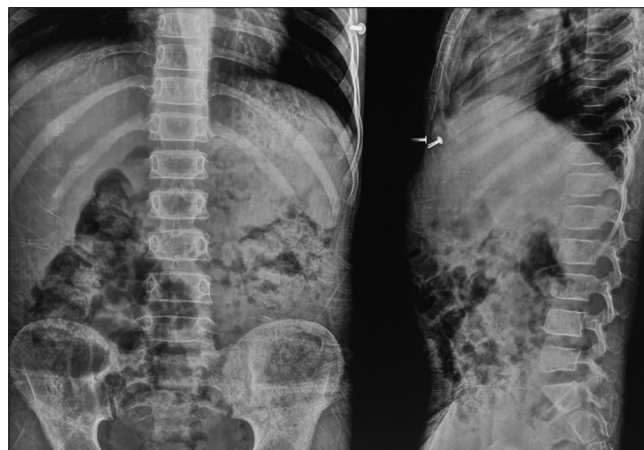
Follow-up X-ray at 12 months showing resolved listhesis and kyphosis by conservative management
